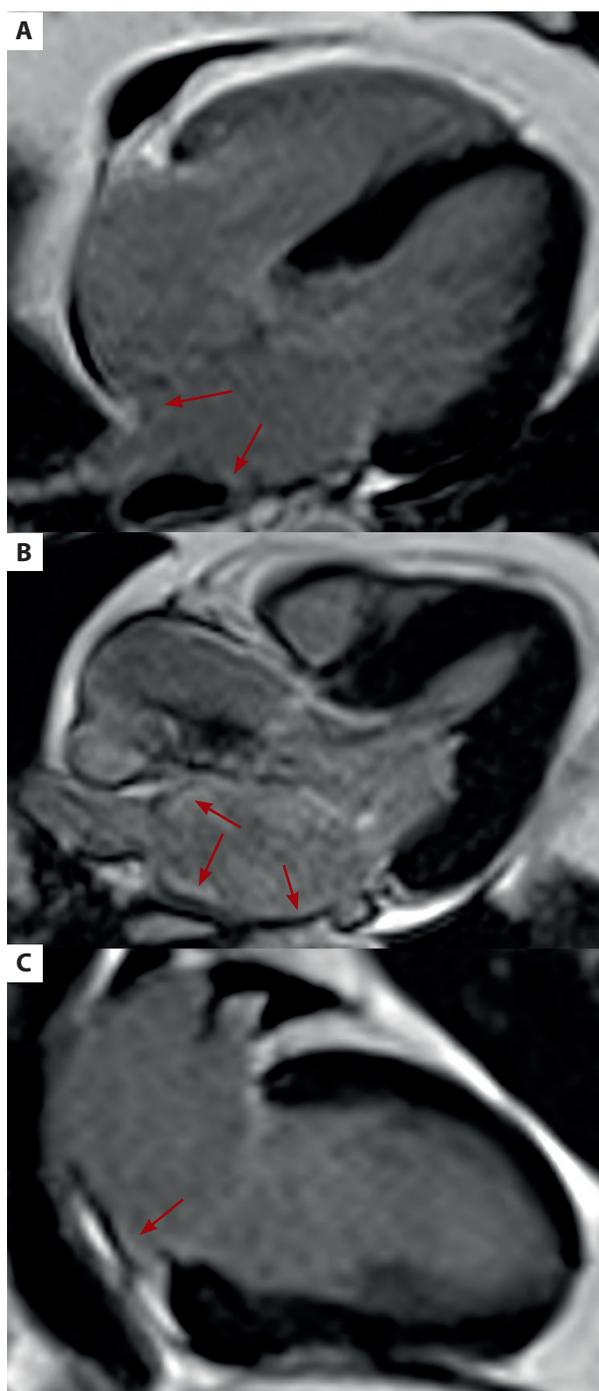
Cardiac magnetic resonance images representing a patient's left atrial late gadolinium enhancement in 4-(A) 4-chamber view, (B) 3-chamber view, and (C) 2-chamber view (arrows)
